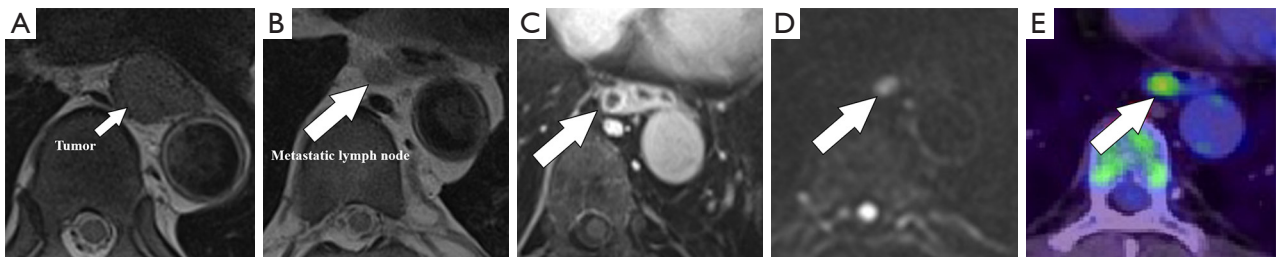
A 55-year-old male esophageal cancer patient with local lymph node metastasis: (A,B) T2WI BLADE, (C) enhanced T1WI StarVIBE, (D) DWI ($b = 800$), and (E) PET/CT. Metastatic lymph node with ring enhancement (white arrow in C), restricted diffusion in DWI ($b = 800$) (white arrow in D) and high ^{18}F -FDG uptake (white arrow in E). T2WI, T2-weighted imaging; T1WI, T1-weighted imaging; StarVIBE, stack-of-stars volume interpolated breath-hold examination; DWI, diffusion-weighted imaging; PET/CT, positron emission tomography/computed tomography; ^{18}F -FDG, ^{18}F -fluorodeoxyglucose.
